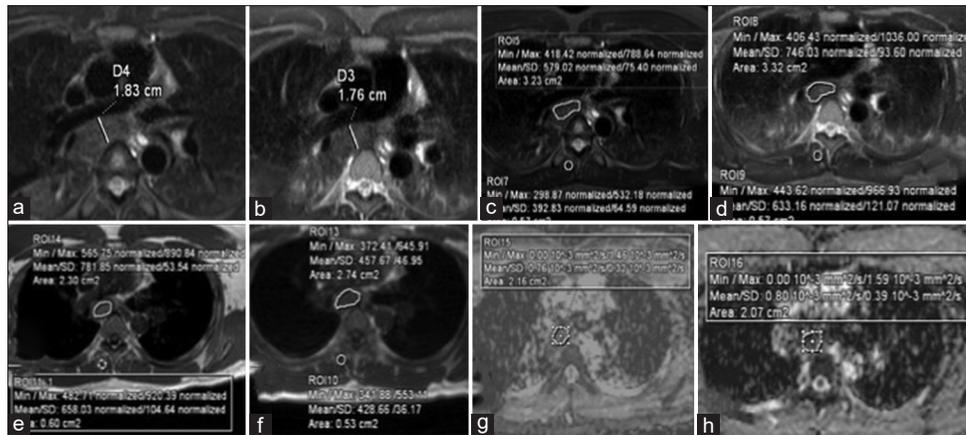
A case of tuberculous mediastinal lymphadenopathy in a 24-year-old female. Interval between first magnetic resonance imaging (a, c, e, and g) and second magnetic resonance imaging (b, d, f and h) was 6 months. On follow-up, lymph node was still of significant size (a and b) and showed low apparent diffusion coefficient values (g and h). However, there was decrease in the T2 and T1 signal intensity ratios (c-f)
